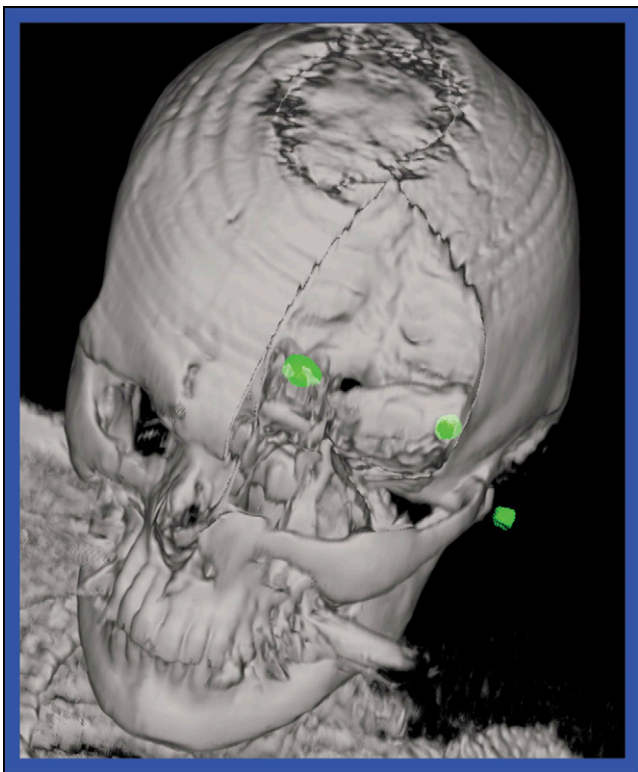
PET/CT Image of the Year. Molecular imaging of a somatostatin receptor-expressing tumor in a 33-y-old man showed additional involvement outside the ear.
